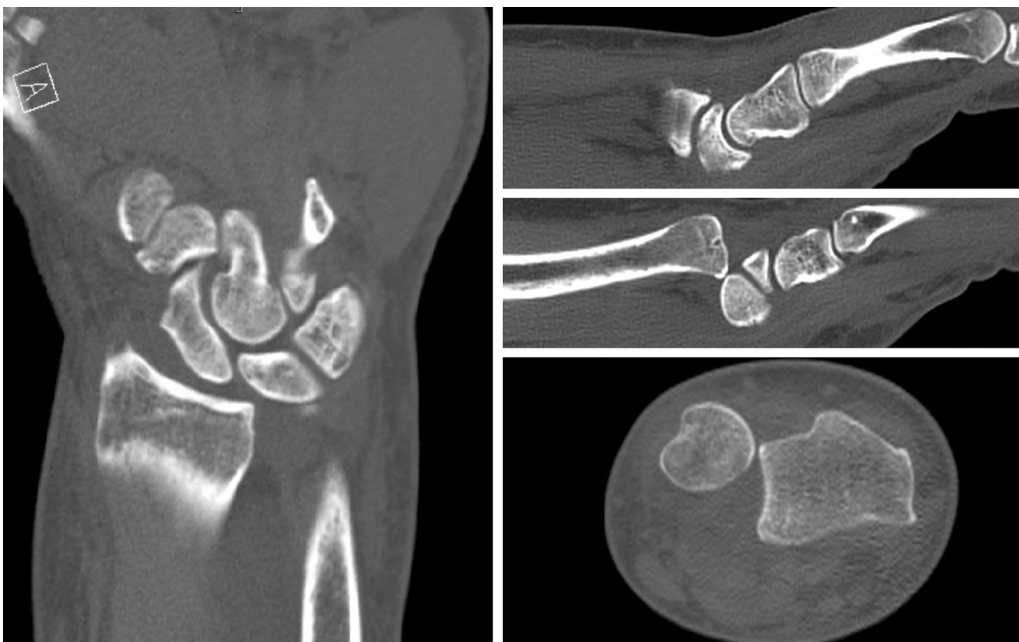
Selected CT images of the initial injury: coronal, sagittal (radiocarpal), sagittal (ulnocarpal), and axial reconstructions (left to right and clockwise). Evidence of ulnar carpal translocation, volar radiocarpal subluxation, and dorsal distal ulna subluxation. CT, computed tomography.
